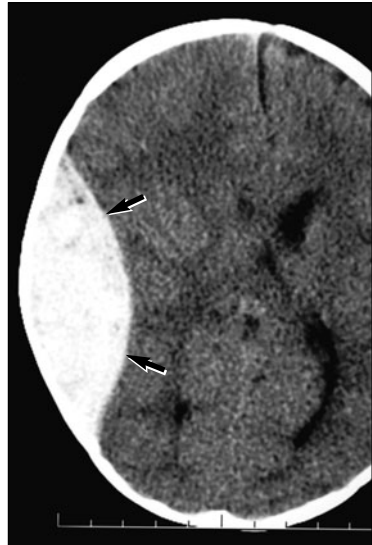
This 11-month-old boy was apparently hit by an older, larger sibling with a toy. The patient was doing reasonably well for a few hours after the injury but had sudden deterioration with loss of consciousness. Unenhanced CT scan demonstrates biconvex, hyperdense, acute epidural hematoma (arrows) in the right parietal region. There is associated mass effect with effacement of the right lateral ventricle and shift of the midline structures. No fracture was seen on bone windows, suggesting that this was a venous epidural hematoma.
